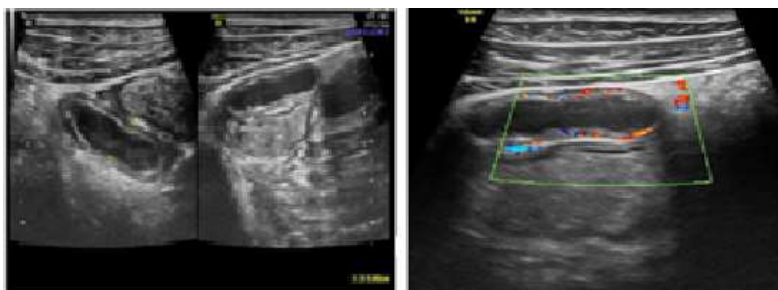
(G,H): G. Longitudinal sonogram of Subhepatic region in a 36 years old female shows findings of Subhepatic Acute Appendicitis. H. Colour Doppler image shows dilated appendix with increased flow in the wall (Grade 5).
